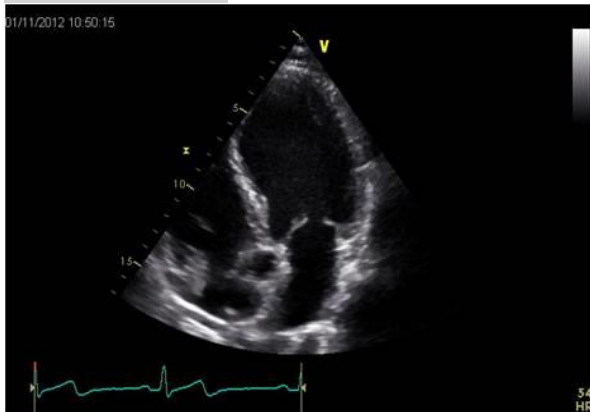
Apical five-chamber view
